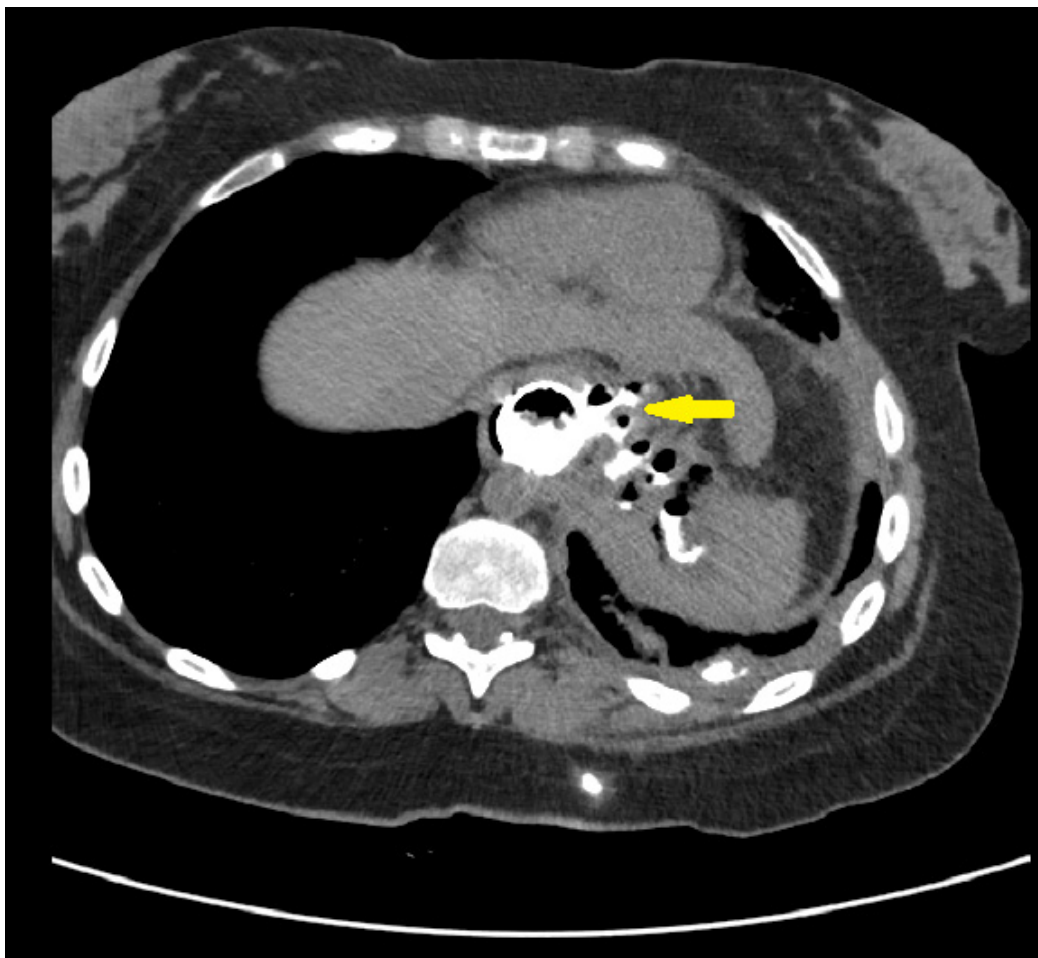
Computed tomographic (CT) scan of the upper abdomen shows leak around the stent (arrow) and tracking around the left side of the abdomen.
